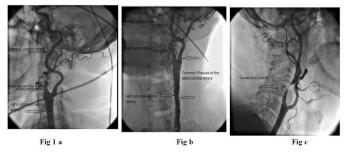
Carotid angiography is performed using X-rays, especially in severe and / or symptomatic carotid artery stenosis or carotid ultrasonography where no healthy information can be obtained. This examination method is still considered the gold standard for the diagnosis of carotid artery disease. During the procedure, a catheter is advanced from the groin or arm artery and the carotid arteries are injected into the carotid arteries. All images belong to Afyon Kocatepe University Faculty of Medicine Cardiology Department Angiography Laboratory. Fig1a. Normal carotid artery angiography image. Right carotid artery and its branches. Fig1b. Left carotid artery. Fig1c: Carotid Artery Stenosis.
